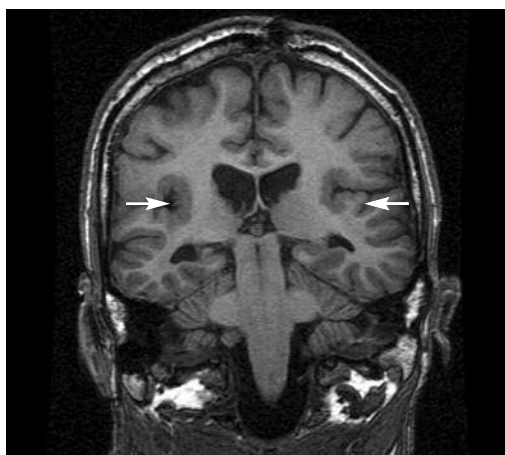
MRI. Coronal section of a young woman with a secondary generalised epilepsy due to a cortical malformation. Note the thickened irregular cortex in the perisylvian regions (arrows).
